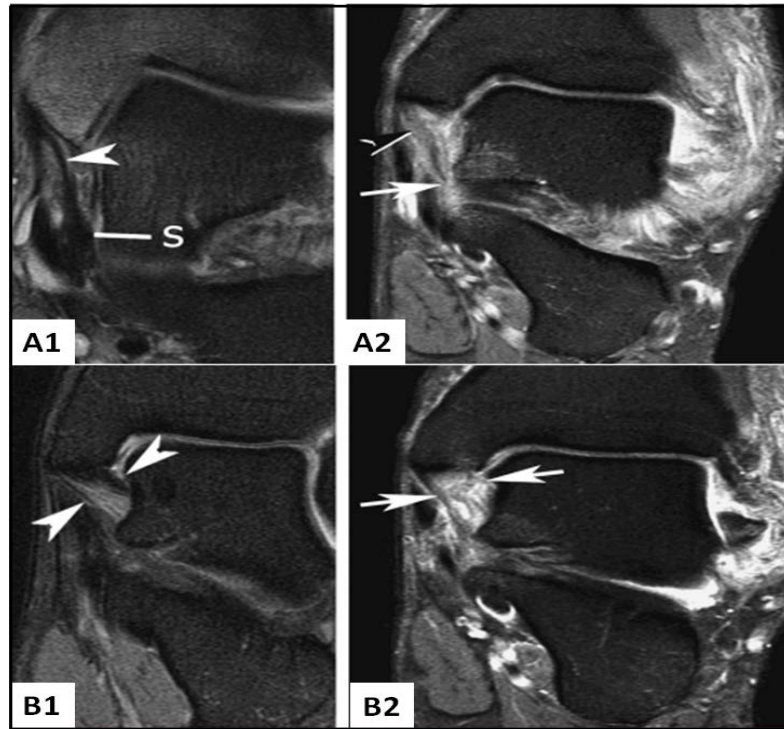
Coronal T2 MRI showing the difference between a normal superficial deltoid (A1) and an injured superficial deltoid (A2): proximal (arrow heads) parts of the ligament look different while the distal (white arrow) part is disrupted; in addition differences in the deep deltoid (arrowheads) in a normal (B1) and an injured deep deltoid (white arrows) in injured ankle (B2) are shown (modified from Koval et al., 2007).
